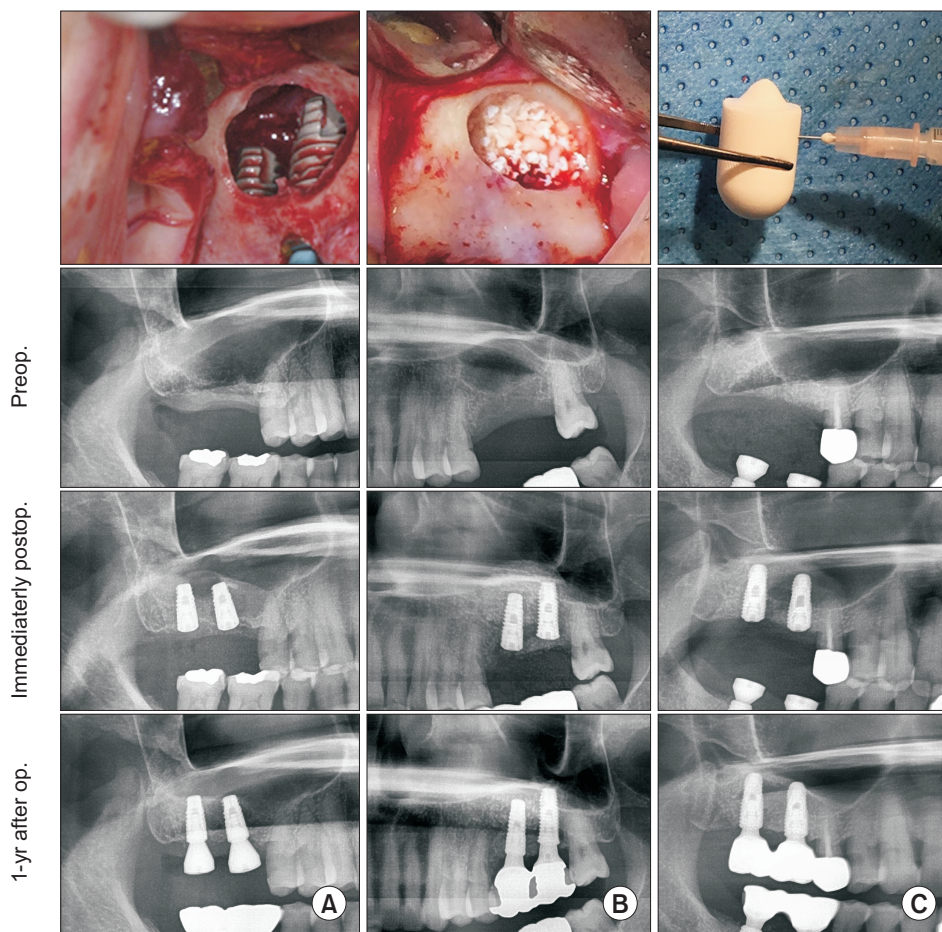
Clinical and radiographic comparison of sinus augmentation. A. No bone graft. B. Particulate bone. C. Recombinant human bone morphogenetic protein-2+absorbable collagen sponge. *Min Seong Kang et al: Comparative study on lateral maxillary sinus augmentation of without grafting, particle bone grafting and recombinant human bone morphogenetic protein-2+absorbable collagen sponge grafting with simultaneous dental implant placement: a retrospective study. J Korean Assoc Oral Maxillofac Surg 2025*
